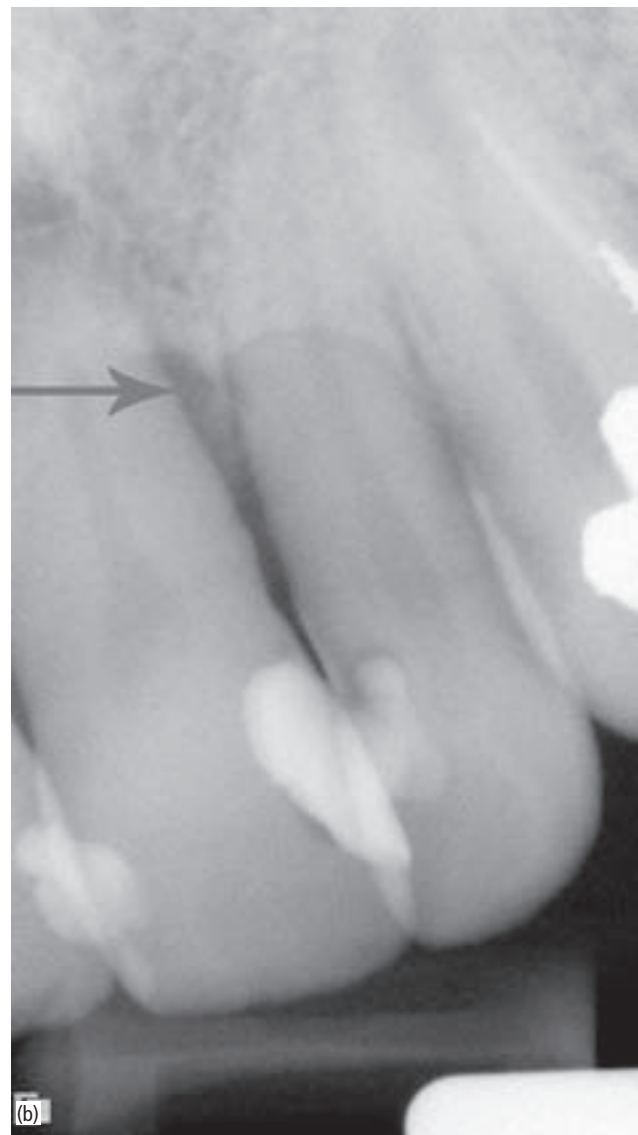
(a) Clinical photograph demonstrating advanced periodontal disease between the left central and lateral incisors. (b) Radiograph demonstrating the extent of the bone loss around the teeth in (a).
